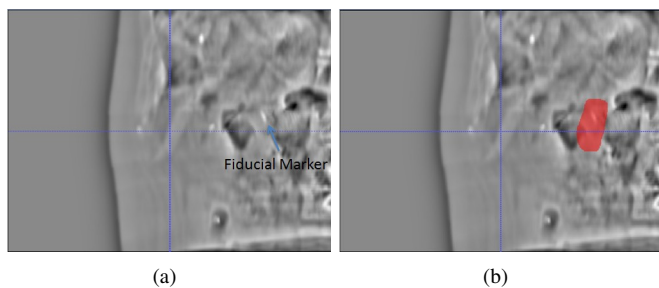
(a) A DRR generated from the mean CT (deformed from the reference CT by  $\mathbf{c} = (0, 0, 0)$ ). (b) Red area indicates the region-of-interest for computing intensity differences between DRR and projection image.
